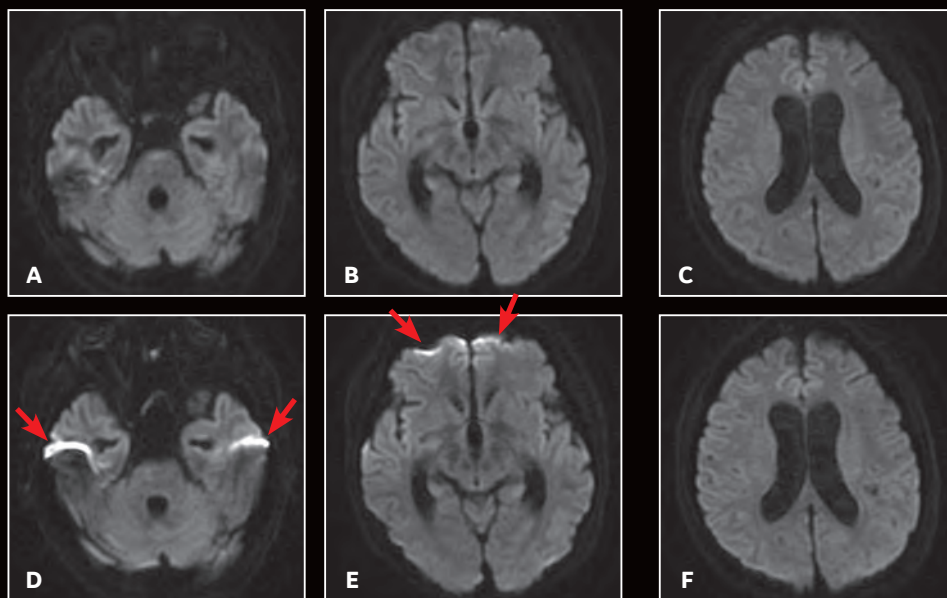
(A-C) DWI with PROGRES; and (D-F) conventional DWI. PROGRES provides less distortion than conventional DWI sequences, including fewer susceptibility artifacts (arrows) around the eye and inner ear.
